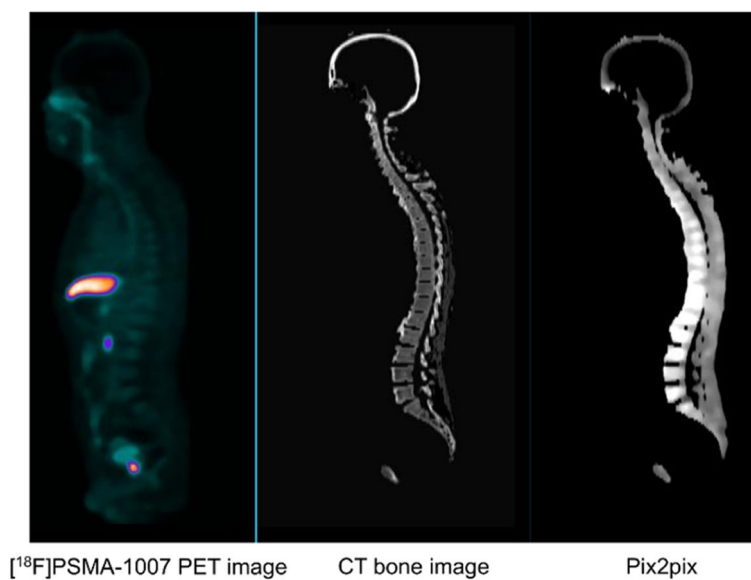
A case of $[^{18}\text{F}]$ PSMA-1007 WB PET bone synthesis image with suboptimal quality at stage M
